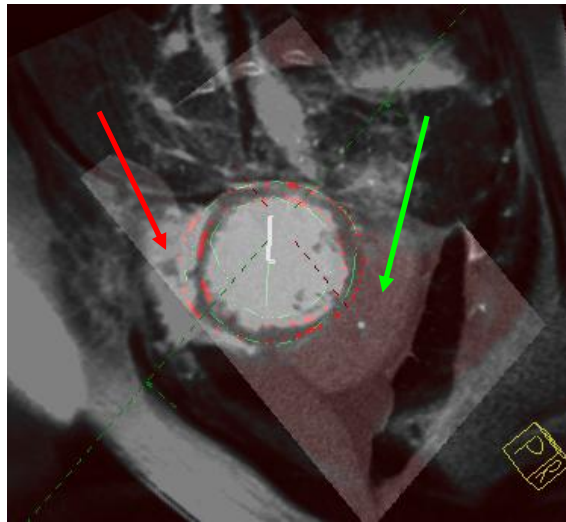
DEMR and CT for Patient 5 before registration. Arrows indicate position of the RV in DEMR (red) and CT images (green).
